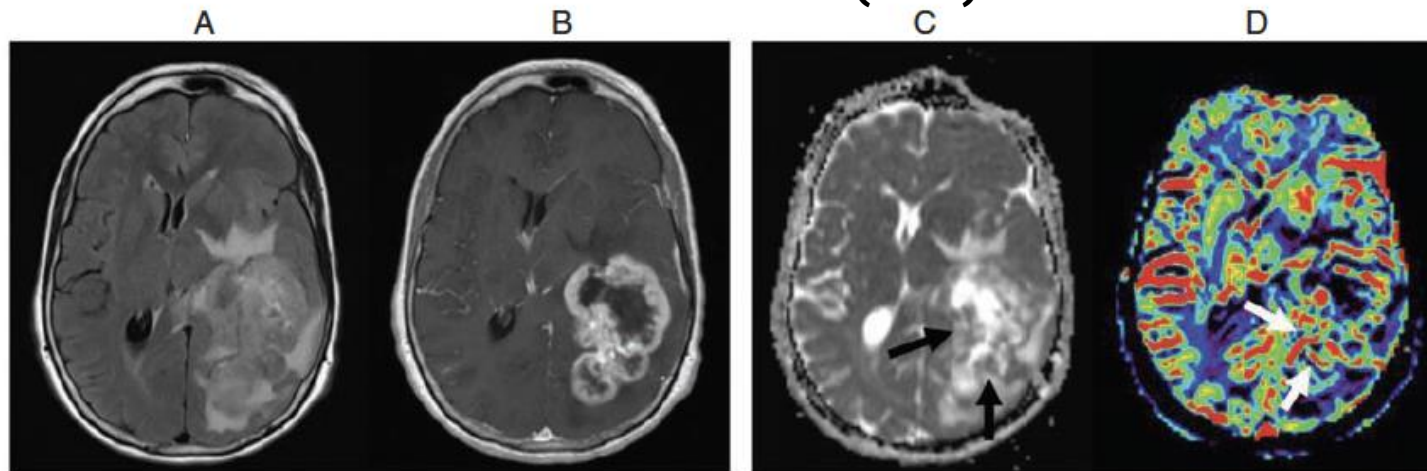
Sixty-four-year-old with a glioblastoma who presented with word finding difficulty. FLAIR (A) and contrast-enhanced T1W (B) images show a large, necrotic-appearing, enhancing mass with surrounding T2/FLAIR signal abnormality in the periventricular regions. There is evidence of hypercellularity on ADC map (black arrow in C) and elevated blood volume on CBV map (white arrow in D)
